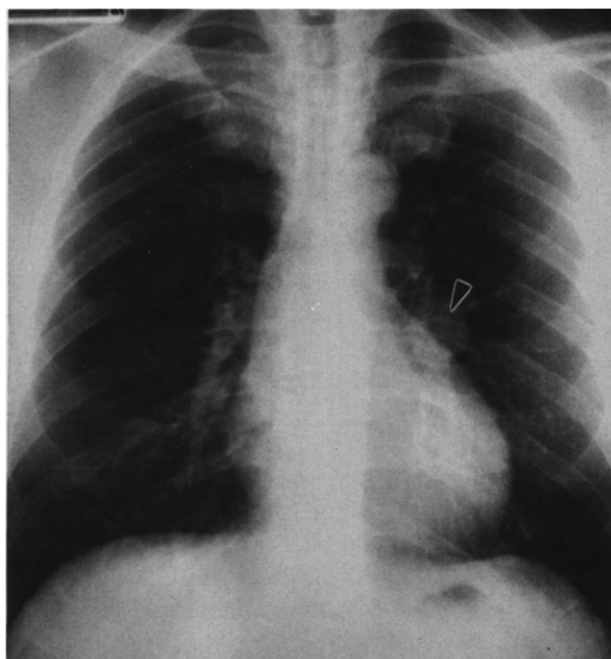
Chest radiograph (case 2) demonstrating a smooth-walled, well circumscribed left hilar nodule (arrow).
